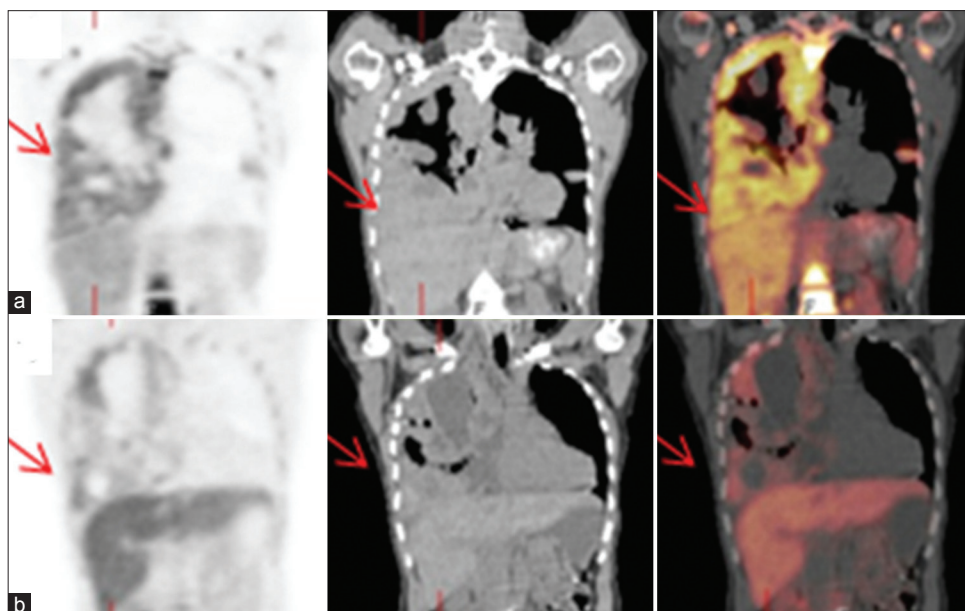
F-18 FLT PET/CT scan. Coronal images: (a) Before treatment and (b) after treatment. A female patient with pleural metastases of a melanoma, showing decreased FLT uptake in the pleural metastases after treatment with Selumetinib for 2 weeks (Patient No. 1) [Table 1]
